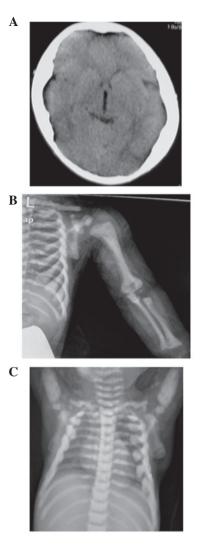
Imaging examinations consisting of a CT scan and X-rays of the proband. A generalized increase in bone density involving (A) the skull, (B) the limbs and (C) the vertebrae was observed. CT, computed tomography.
